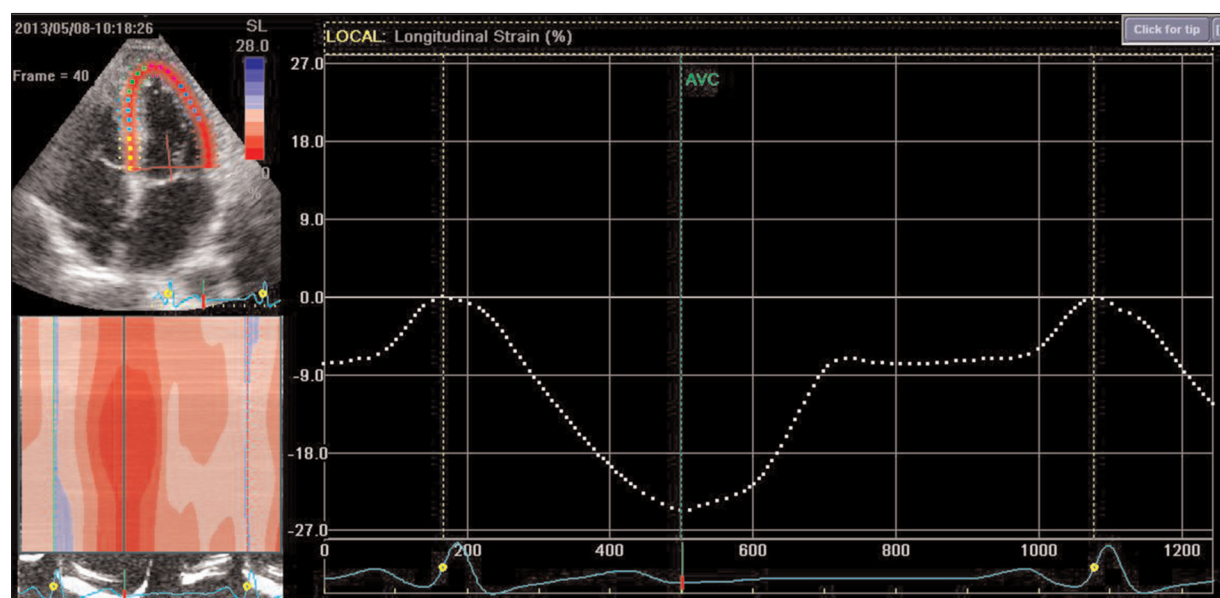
Left ventricular two-dimensional speckle tracking echocardiographic pattern in a patient with Crohn's disease.
